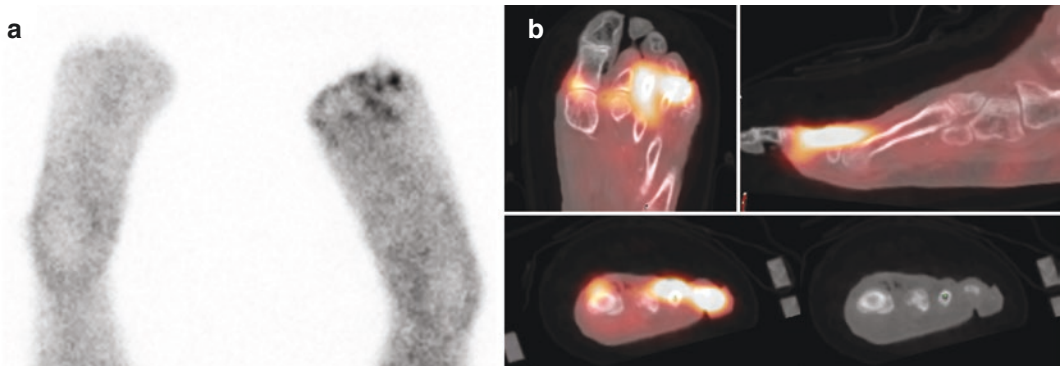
WBC scan and SPECT/CT show cold defects in all of the left toes as well as increased uptake in the soft tissue overlying the 3rd–5th toes (a, b)
